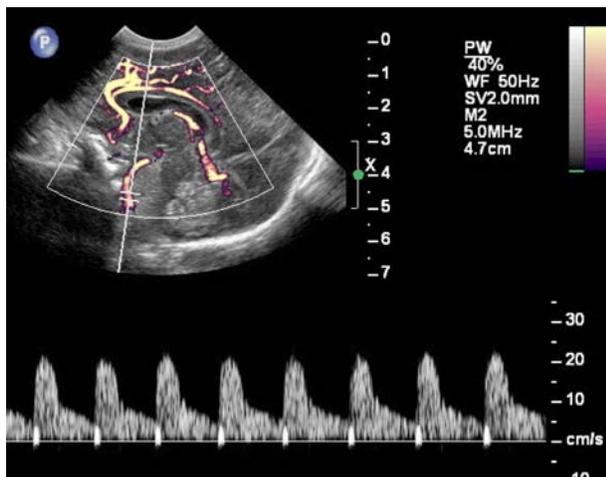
(b) Here a power mode colour Doppler image has been used to guide the placement of a pulsed Doppler sample volume in a neonatal brain.
